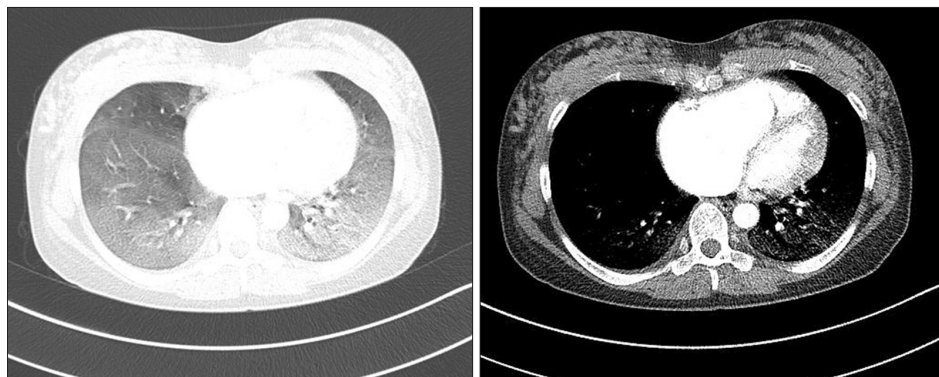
The contrast-enhanced chest computed tomography shows diffuse ground glass opacity in both lungs with dilatation of the pulmonary artery and right ventricle.
